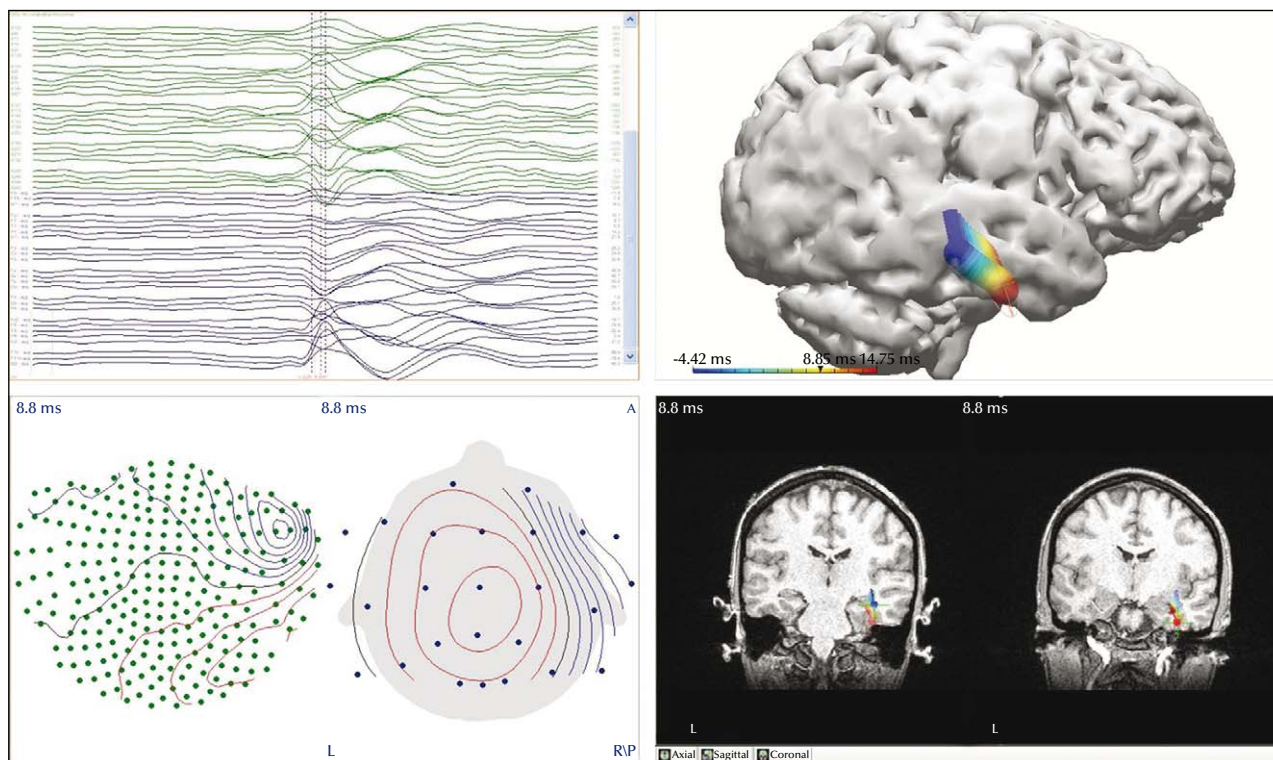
(Patient 1). MEG localized the inter-ictal epileptiform activity in the right basal mid-temporal lobe with anterior propagation. The left panels show the recorded MEG activity. Left upper panel: MEG channels; left lower panel: magnetic field distribution map. The right panels demonstrate the magnetic source co-registered to the patient's MRI. Right upper panel: three-dimensional head model; right lower panel: coronal high volume MRI acquisition. Note the anterior propagation of the magnetic field on the 3D model and the coronal MRI (courtesy of Dr John Ebersole).
